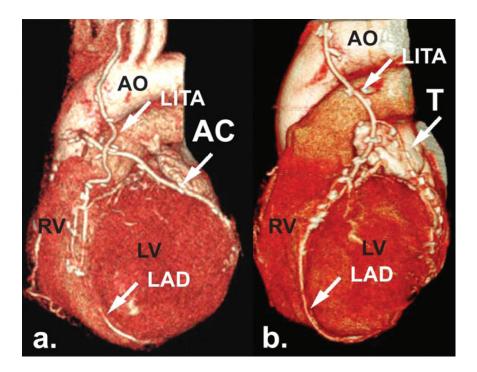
256 slice computed tomography volume-rendering image in the left anterior oblique projection. (a.) the radial artery (aortocoronary graft) to the obtused marginal branch of the left circumflex artery (b.) the radial artery (T graft from the left internal thoracic artery) to the obtused marginal branch of the left circumflex artery.
